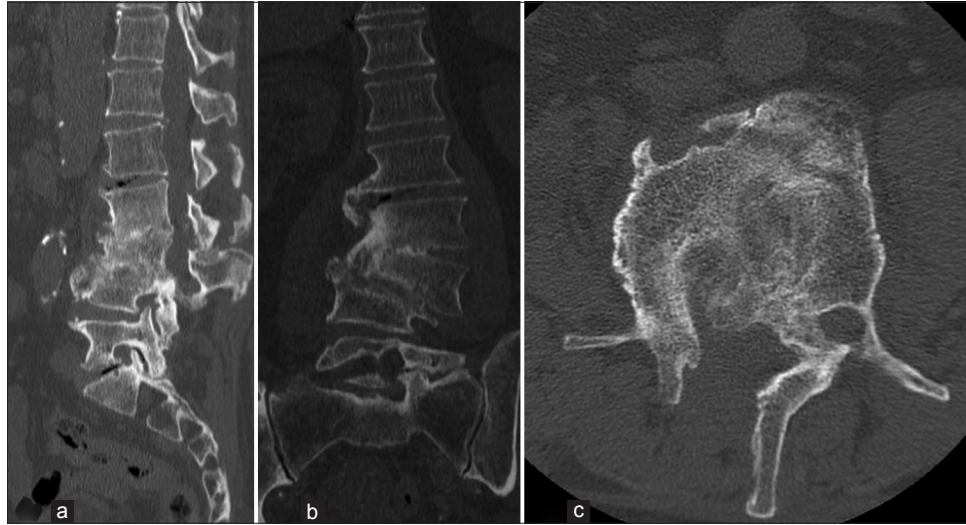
(a) Sagittal, (b) coronal, and (c) axial computed tomography scan images at 12 months follow-up, showing vertebral fusion of L2-L3-L4.
